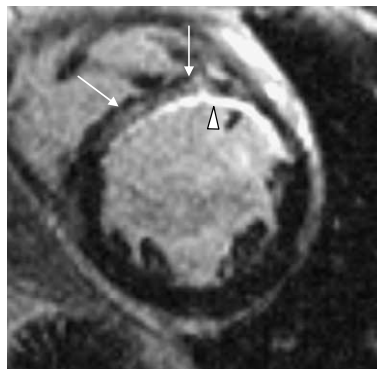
Short axis view in a patient with old anteroapical infarction. Lipomatous metaplasia (markers) leads to phase cancellation and signal loss in SSFP cine imaging (a), regional high signal intensity in T1-weighted spinecho imaging (b) and very low signal in T2-weighted spinecho imaging with fat suppression (c). See also subcutaneous fat (arrows).
